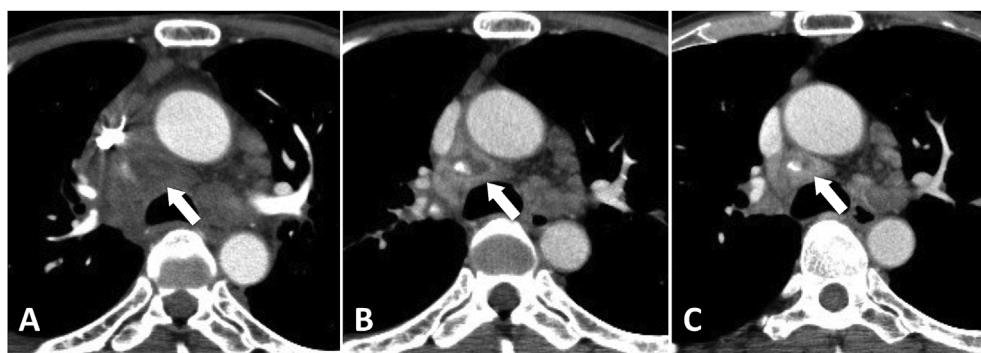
Computed tomography on day of admission (A), 2 weeks (B), 4 weeks (C) after treatment. The 4R lymph nodes were shrinking gradually after treatment.
